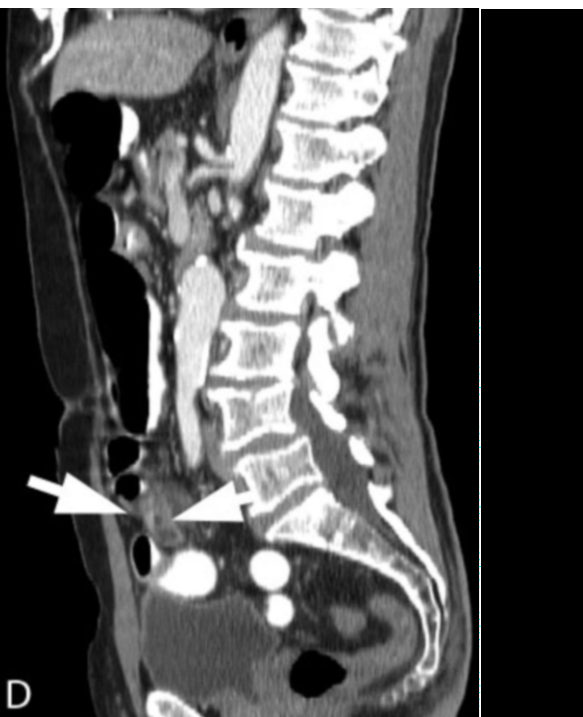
(C) Coronal CT reconstruction shows fluid-filled diverticulum (arrow) emerging from anti-mesenteric border of bowel. (D) Sagittal CT reconstruction shows a diverticulum descending from the inferior border of the small bowel (arrow).
